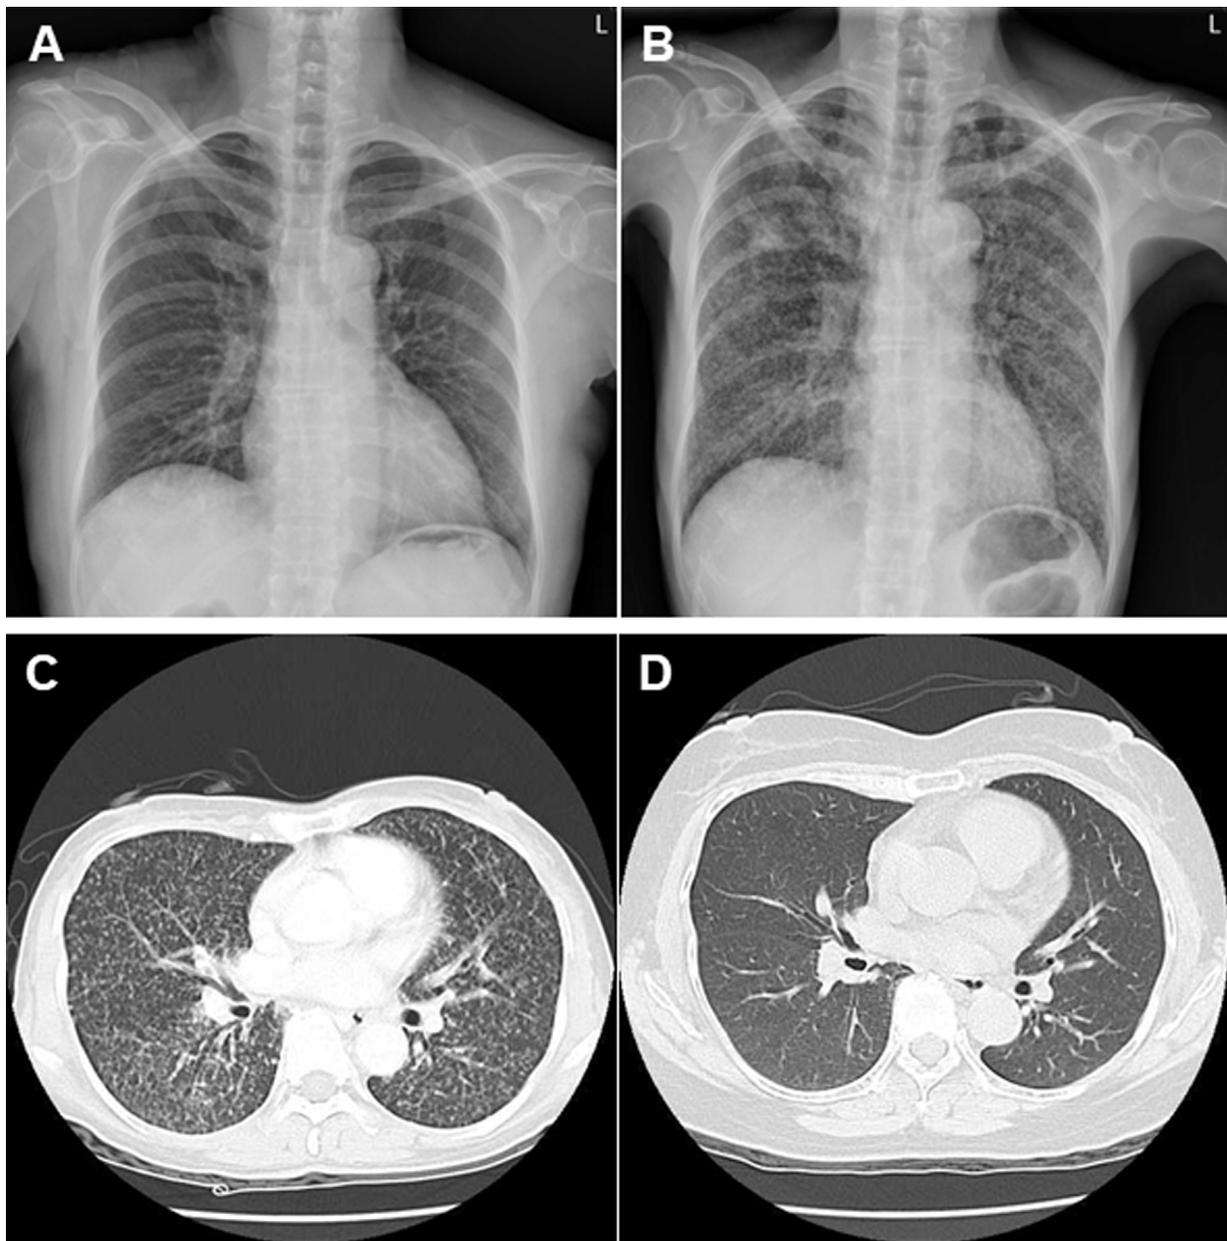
Clinical images of miliary TB in a RA patient receiving TNF mAb therapy. (A). A clear chest X-ray without any lung lesions before starting TNF mAb therapy. (B). Bilateral diffuse miliary lesions on chest X-ray after TNF mAb therapy. (C). Bilateral innumerable micronodular opacities on chest computed tomography after TNF mAb therapy. (D). Resolved bilateral miliary nodules on chest computed tomography after anti-TB treatment.
